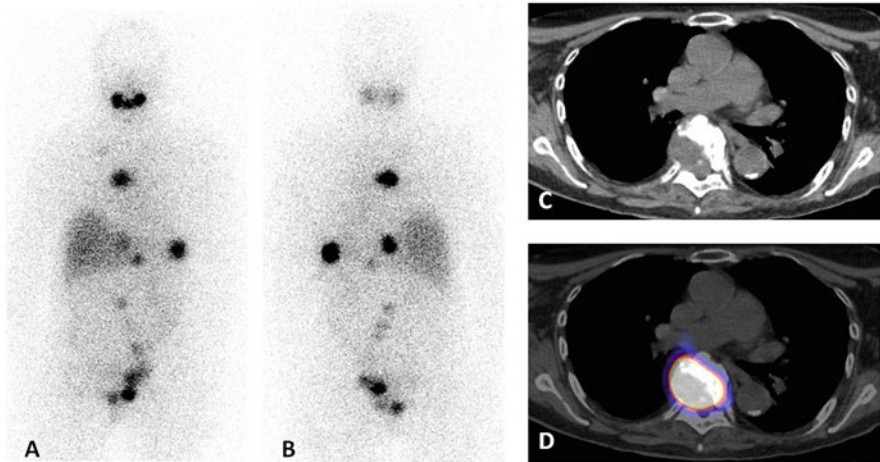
^{131}I post therapy scan of a patient with follicular thyroid carcinoma. Planar images (a) anterior view, (b) posterior view): bone metastases in the vertebral column and in costa 11 on the left side. (c) CT image with destruction of Th6. (d) Fusion SPECT/CT image with high uptake of ^{131}I in Th6
